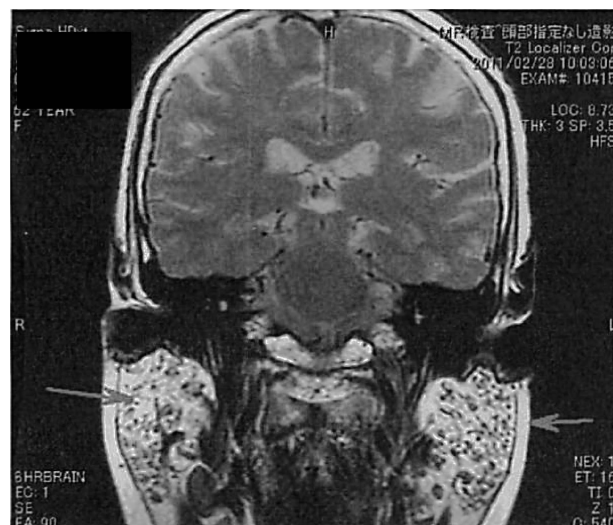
MRI with gadolinium contrast revealed a mottled appearance of the parotids, which was compatible with Sjögren's syndrome.
